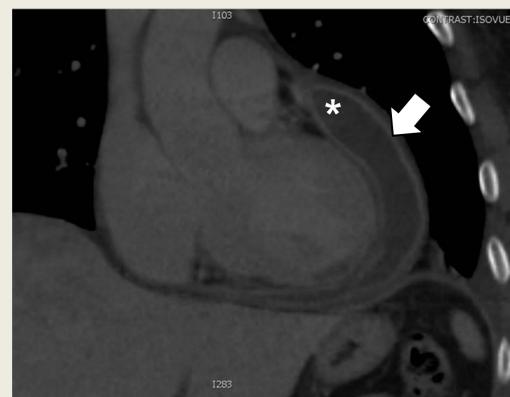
Contrast enhanced computed tomography of the chest on day 31 demonstrating large complex density pericardial effusion (star) and extensive thickening with delayed enhancement of the pericardium (white arrow).
